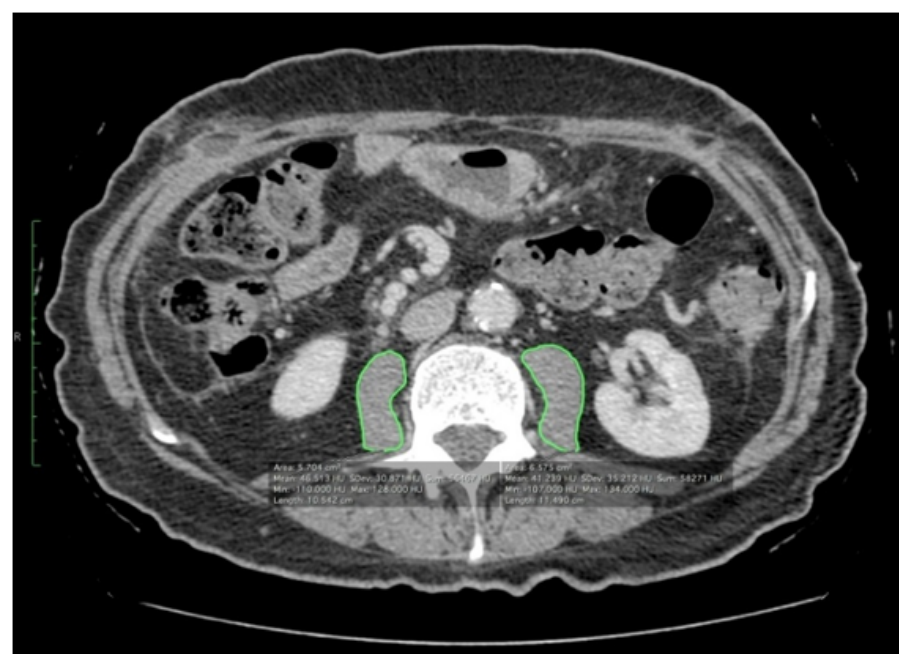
CT scan with manual presentation of borders of large lumbar muscles at level 3 of lumbar vertebra.
